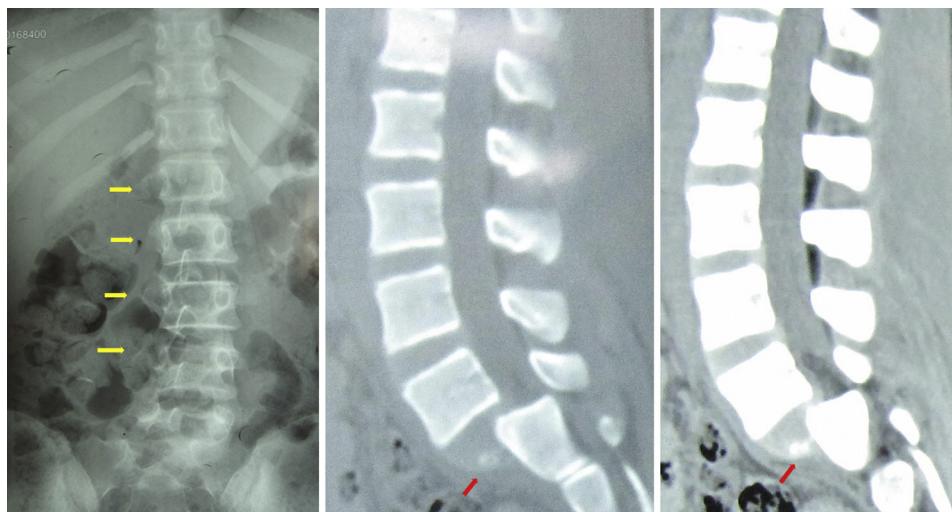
Radiographs after injured. (Left) Anterior-posterior view of X-ray, yellow arrows show unilateral transverse processes fracture. In (Middle) soft-tissue window and (Right) bone window of computed tomography, red arrow shows physeal cartilage of S1 superior end plate.
